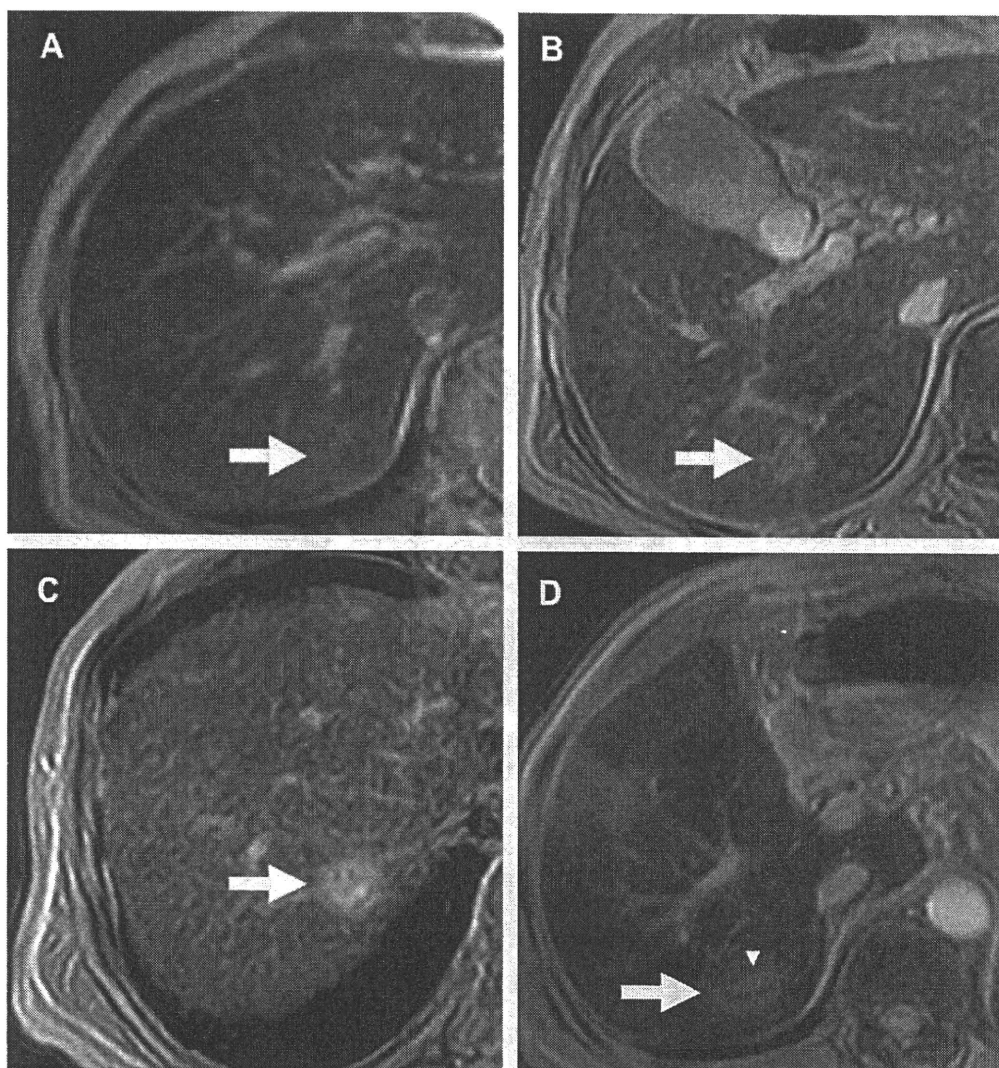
T2-weighted GRE images (TE, 9.5 ms) after administration of SPIO in well-differentiated hepatocellular carcinoma (HCC) shows various signal intensities depending on Kupffer cell function within the nodule (A–D) (arrow). A dysplastic nodule with a central focus of HCC is observed as “a nodule within a nodule” (D) (arrowhead).
